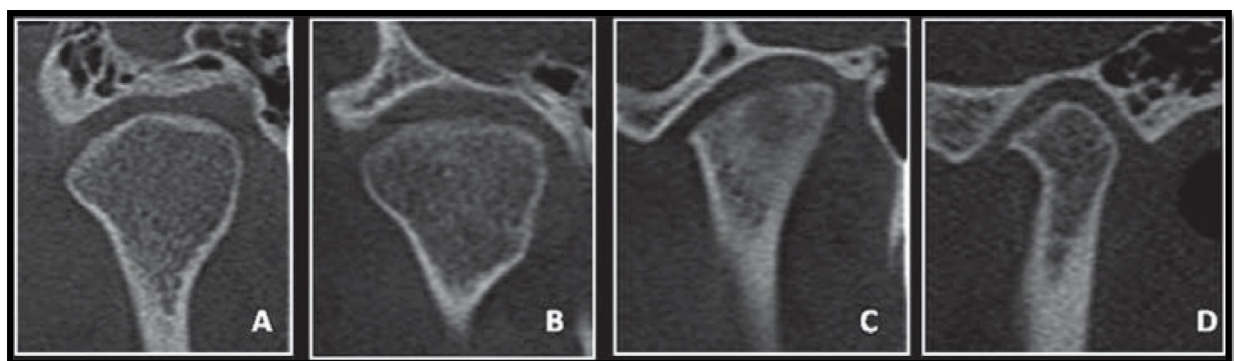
Cone-beam computed tomography images of temporomandibular joint showing morphological variation of the mandibular condyle. A- Normal (coronal view); B- Flattening (coronal view); C- Erosion (coronal view); and, D- Osteophyte (sagittal view) (Valladares-Neto J. 2014).
